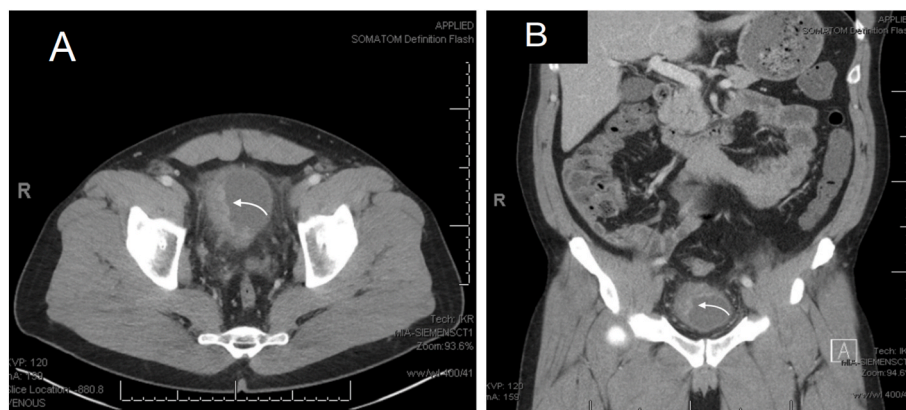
A) Pelvic axial CT scan showing diffuse abnormal thickening of the bladder's right lateral wall (arrow). B) Abdominal and pelvic coronal CT scan showing diffuse abnormal thickening of the bladder's right lateral wall (arrow)
